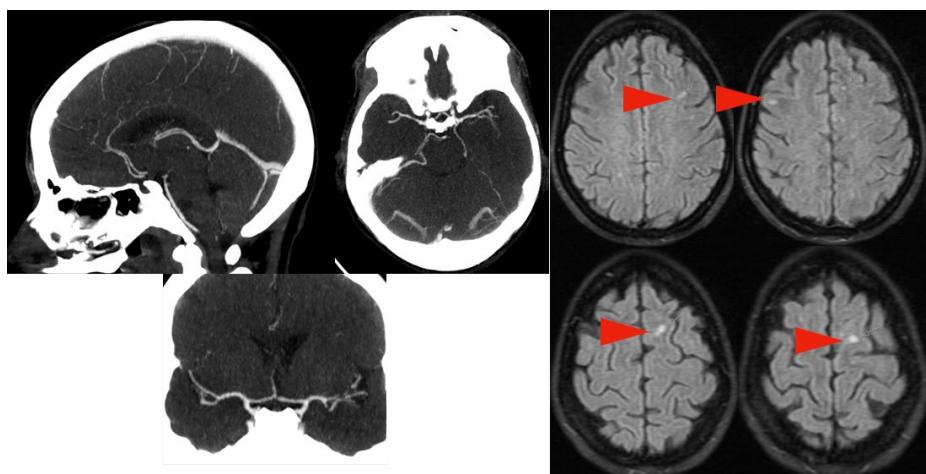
Left: Head MRI with contrast showing right internal carotid, middle cerebral arteries, intracranial vertebral arteries, and posterior cerebral arteries vasculitis (irregularities, narrowing, and stenosis). And Right: Head MRI without contrast showing vasculitis areas (arrows pointing high signal intensity).
